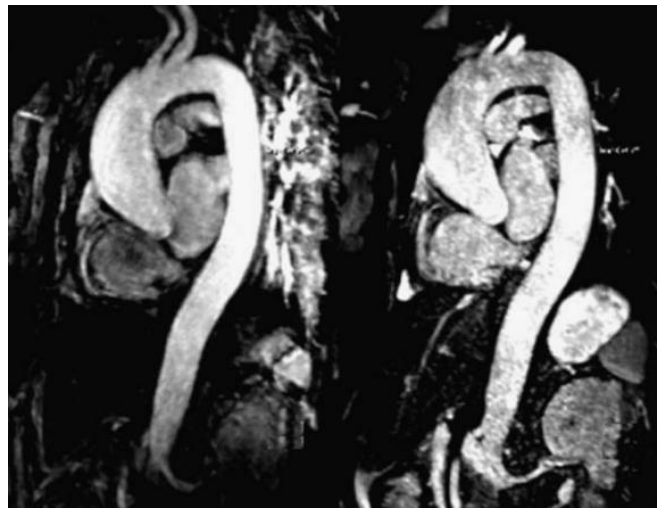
MR images in a 59-year-old patient suffering from aneurysm of the aorta root obtained with CE-MRA (left) and unenhanced MRA (right) sequence. (Reproduced from Xu *et al.*¹⁷⁹, with permission from John Wiley & Sons)
